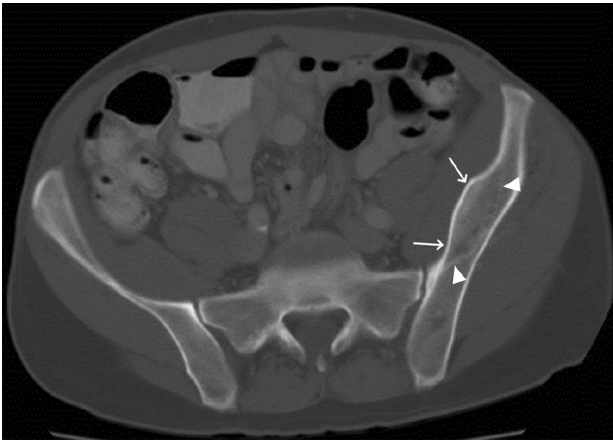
20-year-old male with a chronic ossified subperiosteal hematoma of the left iliac bone. Axial pelvic CT images show a lens-shaped, expansile mass in the medial aspect of the left iliac bone with peripheral ossification (arrow). Note the dense line representing the native cortex of left iliac bone, termed the “ghost native cortex” sign (arrowheads)
